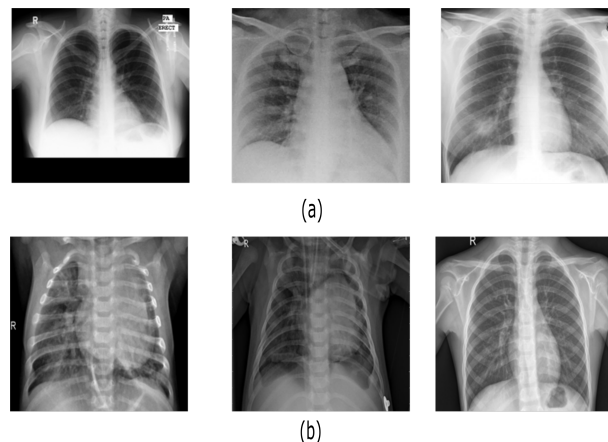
Examples of a) labelled chest X-ray images (from left to right: normal, COVID-19, and SARS images), and b) unlabelled chest X-ray images used in this work for self-supervision learning.
